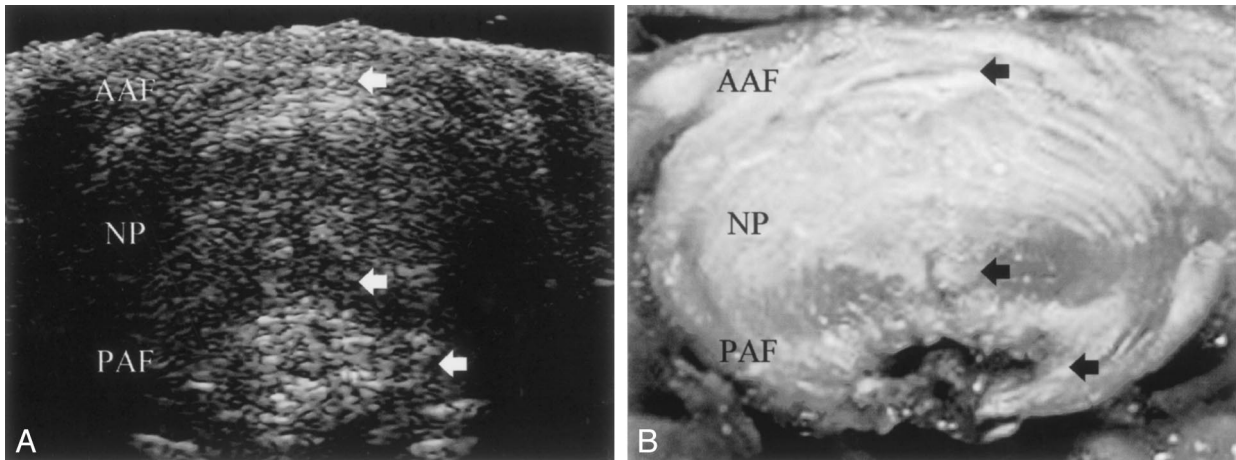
A, Ultrasonic image of an intervertebral disc. Arrows indicate the positions of gross pathologic defects. B, Photographic image of the intervertebral disc pictured in a. Arrows indicate the positions of gross pathologic defects.
